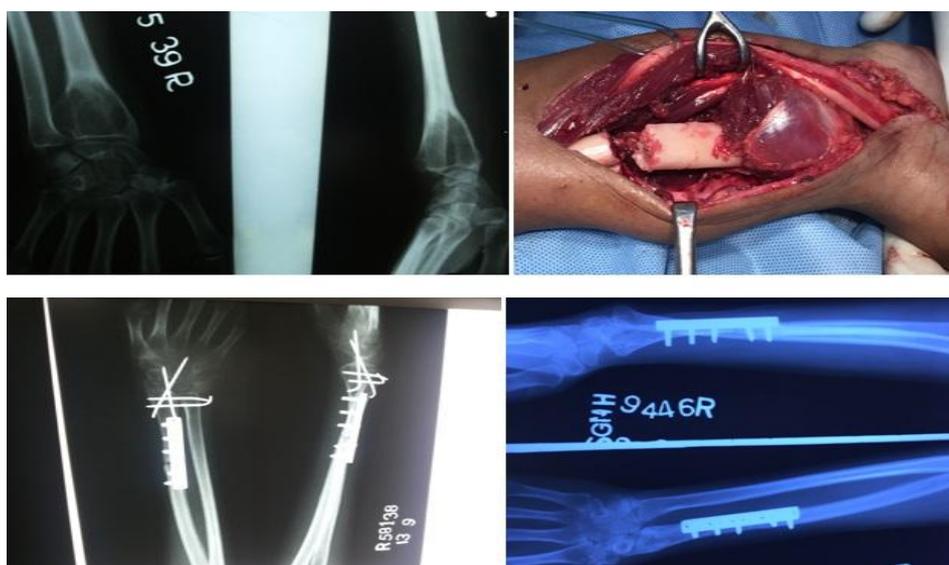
a) Upper half shows pre-operative & intraoperative image in 35yr female with grade 3 GCT distal end radius. b) Lower half shows immediate post-op as well as 6 month follow-up x-rays showing radio-fibular union. Patient had an excellent outcome
